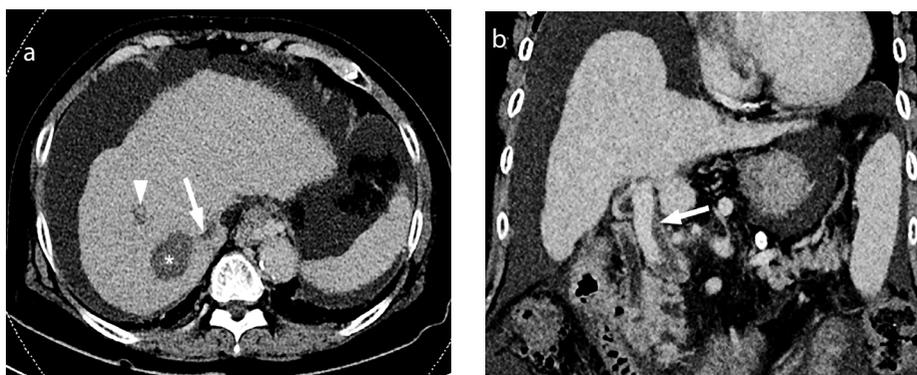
(a, b) Portal vein and hepatic vein thrombosis after microwave ablation of a segment 7 hepatocellular carcinoma. Axial contrast-enhanced computed tomography (CECT) (one month follow up) image (a) in the venous phase shows adequate ablation of the lesion (asterisk) with the formation of partial thrombus within the adjacent right hepatic vein (arrow) and portal vein (arrowhead). Coronal CECT image (b) in the venous phase demonstrates the extension of the partial thrombus into the main portal vein (arrow).
